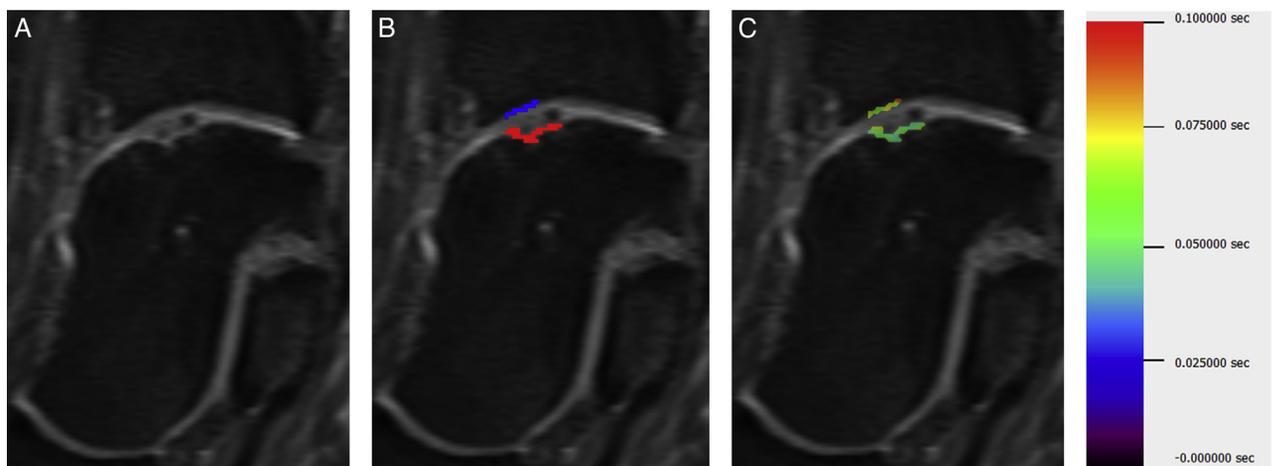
(A) Representative lateral ankle magnetic resonance image at 7 Tesla demonstrating talar osteochondral lesion of subject 6; (B) segmented talar osteochondral lesion (red) and corresponding tibial lesion (blue); and (C) the corresponding T2 relaxation color map.
